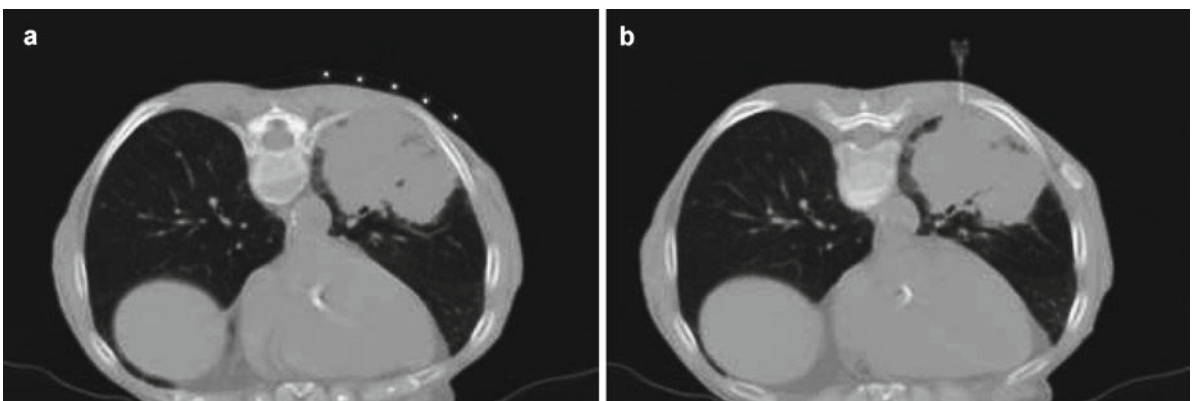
CT-guided lung biopsy in an 83-year-old patient with a history of non-Hodgkin's lymphoma and a suspected pulmonary relapse. The biopsy confirmed the relapse
